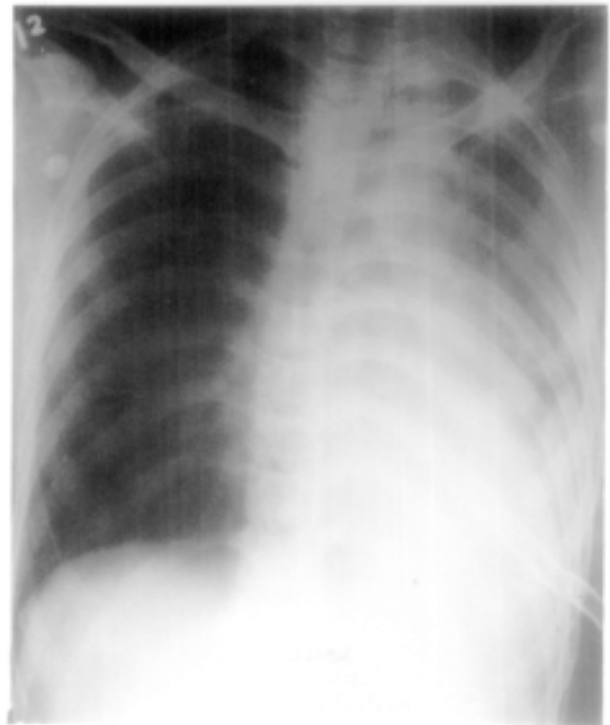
Chest radiograph (postero-anterior view) of the same patient following surgical repair showing significant expansion of the right lung.
